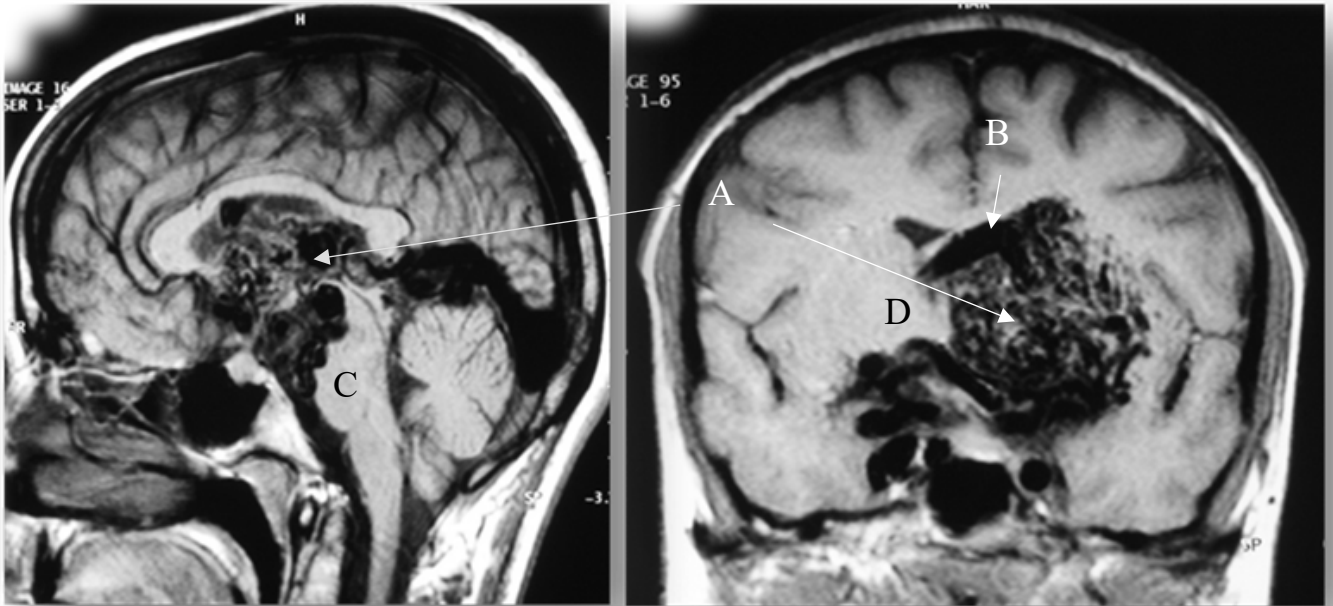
Multiplanar MRI demonstrating a high-grade left-sided thalamic AVM. The AVM is located within the left thalamus with deep venous drainage. A denotes the AVM nidus and B demonstrated an enlarged draining vein (similar to Figure 1-1). C denotes the brain stem and D denotes the normal contralateral thalamus. Figure courtesy of Professor Marcus Stoodley.
